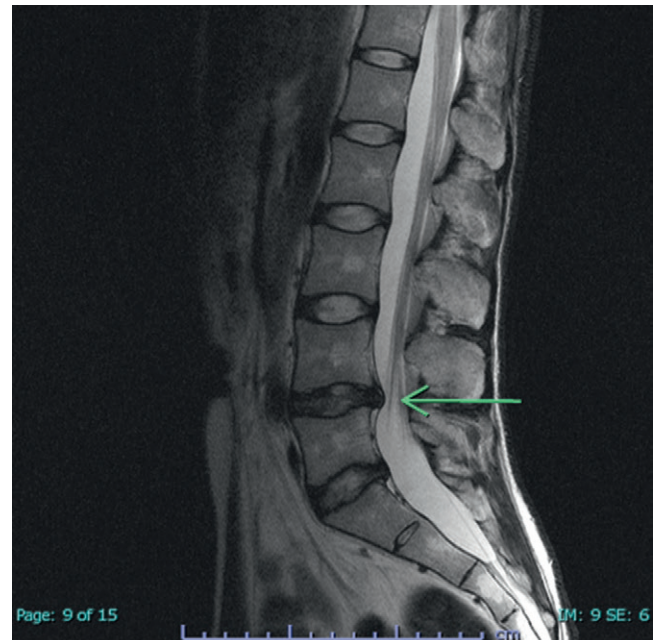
MRI of the lumbar spine, herniated disc
